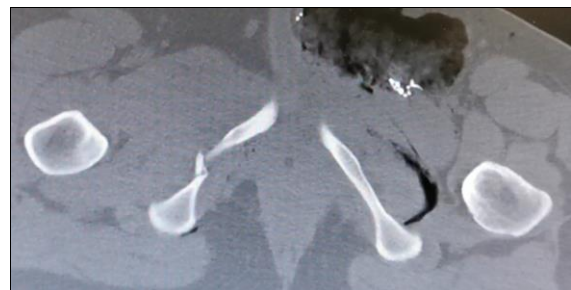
CT-scan axial cut of the right ischiopubic ramus fracture
